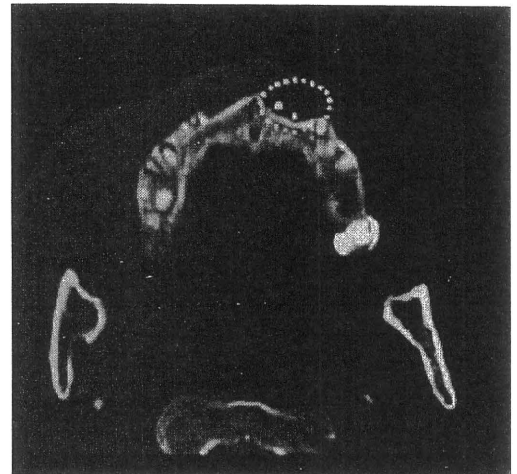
CT scan showed osteolysis of the maxillary bone and implant root exposure.
